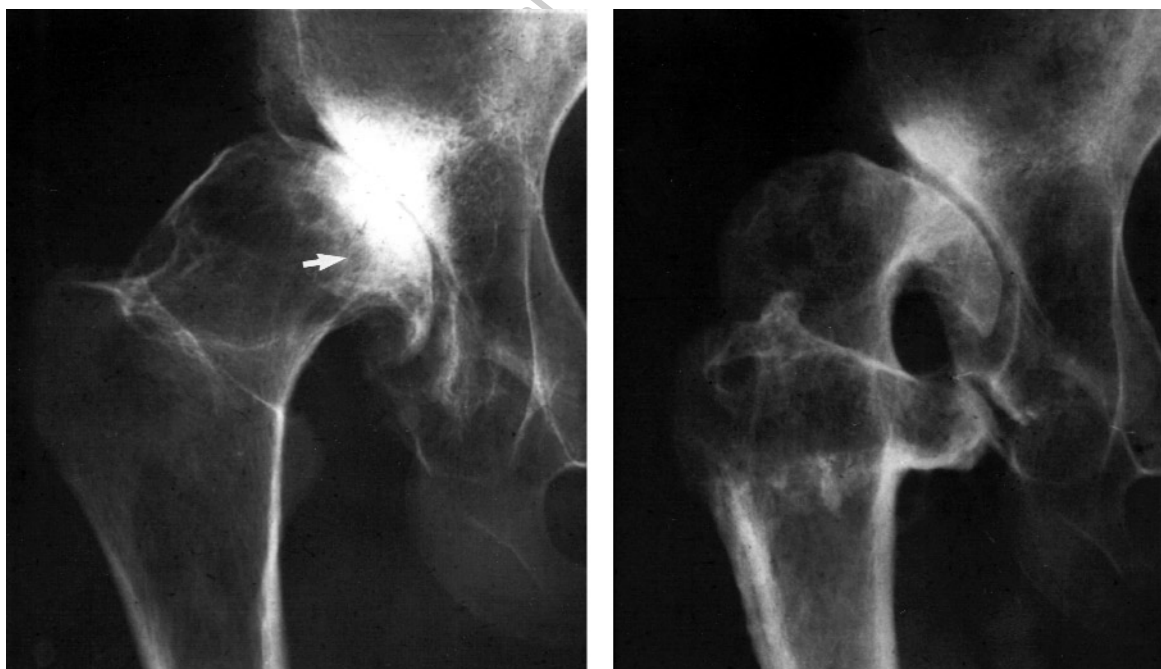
Radiographs of a 36-year-old woman with hip dysplasia that led to OA. Left panel shows a radiograph obtained prior to osteotomy. Right panel shows the same hip 7 years after a successful osteotomy. During surgery, the alignment of the femur was altered so that the large beak osteophyte (arrow) was shifted to the weight-bearing region of the joint. Note the striking decrease in subchondral sclerosis and regrowth of the joint space after surgery.
